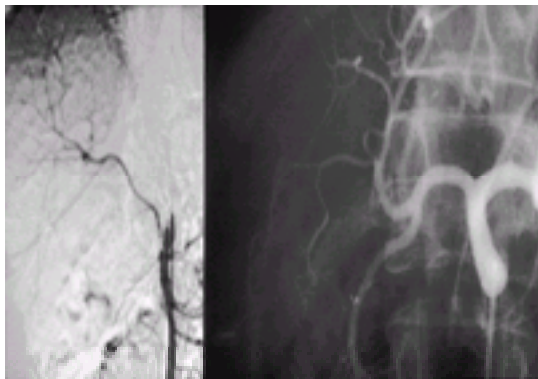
Hepatic angiogram showing one of the common anomalies. The left hepatic artery arises from the coeliac plexus (the radiograph on the right) but the right hepatic artery comes from the superior mesenteric artery (the radiograph on the left). This arrangement is found in about 25 per cent of patients.
